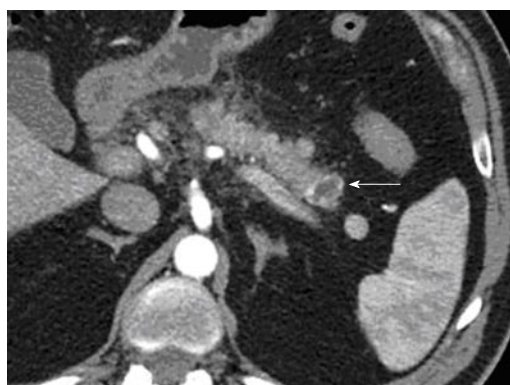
Computed tomography scan showing thin residual hypervascular tissue (white arrow) two months after the first treatment.
